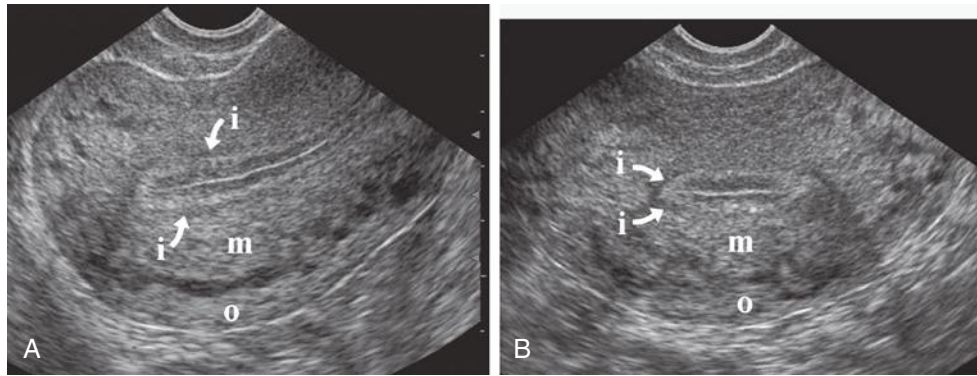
Myometrial layers. Transvaginal longitudinal (A) and transverse (coronal) (B) sonograms demonstrating the three layers of the myometrium: the outer (o), intermediate (m), and hypoechoic inner (i) layers (arrows).
